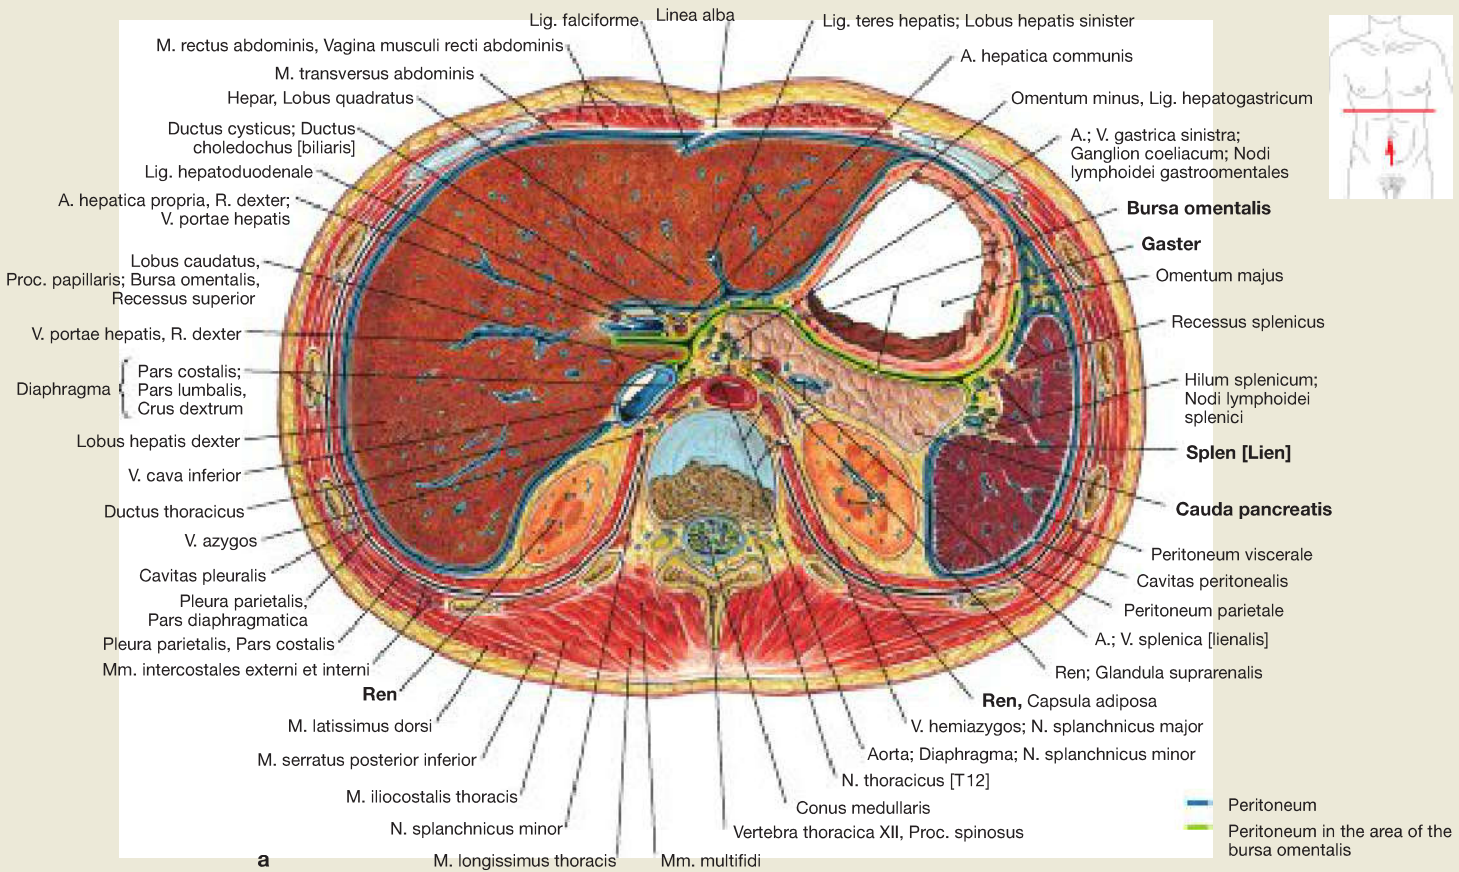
Abdominal cavity, Cavitas abdominalis; cross-section at the level of the 11<sup>th</sup> thoracic vertebra (→ Fig. 6.140a) and corresponding computed tomographic cross-section (CT; → Fig. 6.140b); caudal view. a [L238], b [T832]
